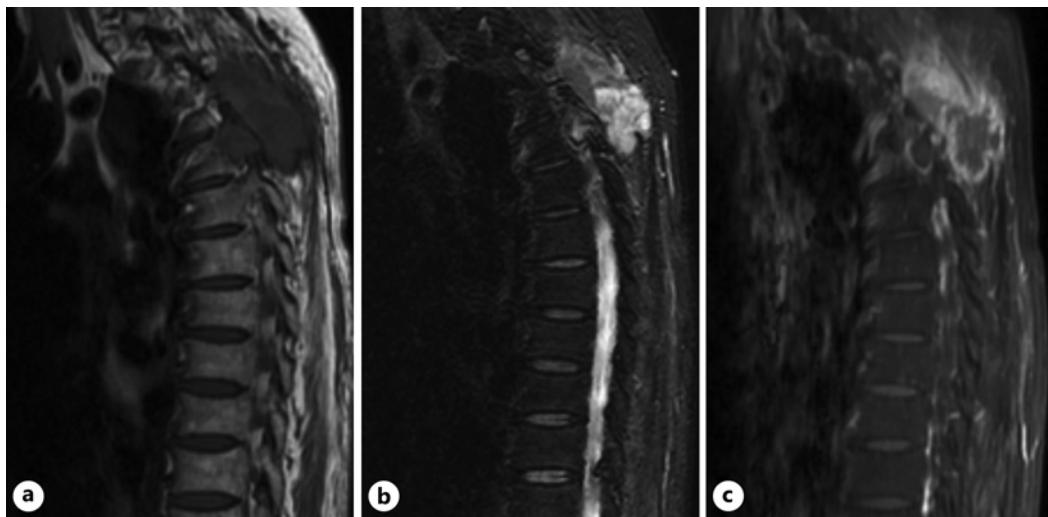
a Magnetic resonance imaging demonstrates invasive and uneven low signal intensity within the erector spinae muscles at the T1–5 level on T1-weighted images. T2-weighted images reveal an infiltrative mass with high signal intensity (b), displaying diffuse and nonuniform enhancement, spreading to the right paravertebral area and the extradural space (c).
